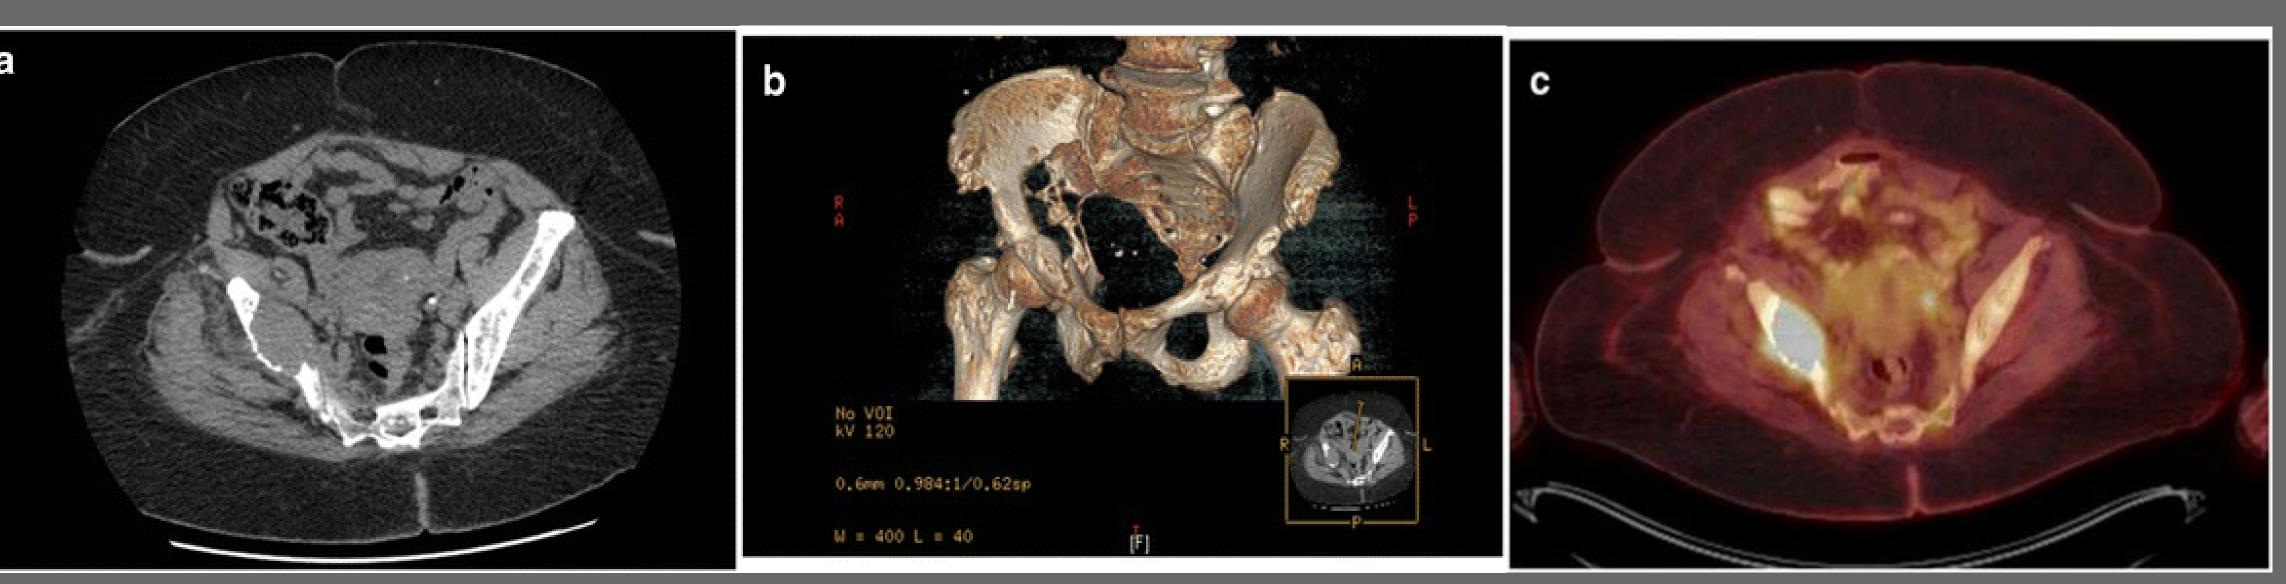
"Panel a shows a large lytic destructive lesion of the right acetabulum extending into the right iliac bone extraosseous extension. Panel b shows CT with volumetric rendering of the same lesion. Panel c shows SUV 41.1 over the right iliac lytic lesion."³
